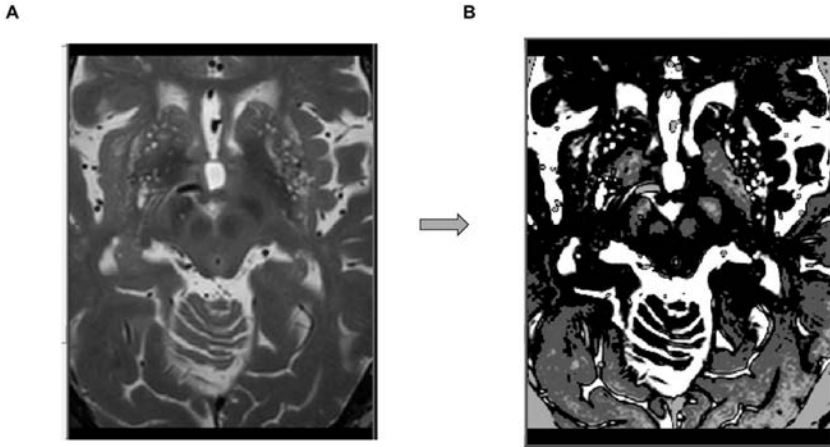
A. Preoperative T2 weighted MRI used to segment the relevant tissue types. B. Same slice after segmentation and designation of the corresponding conductivity values. CSF represented with high intensity values (white); grey matter with lower intensity values (light grey regions); and white matter with the lowest values in this image (black).
